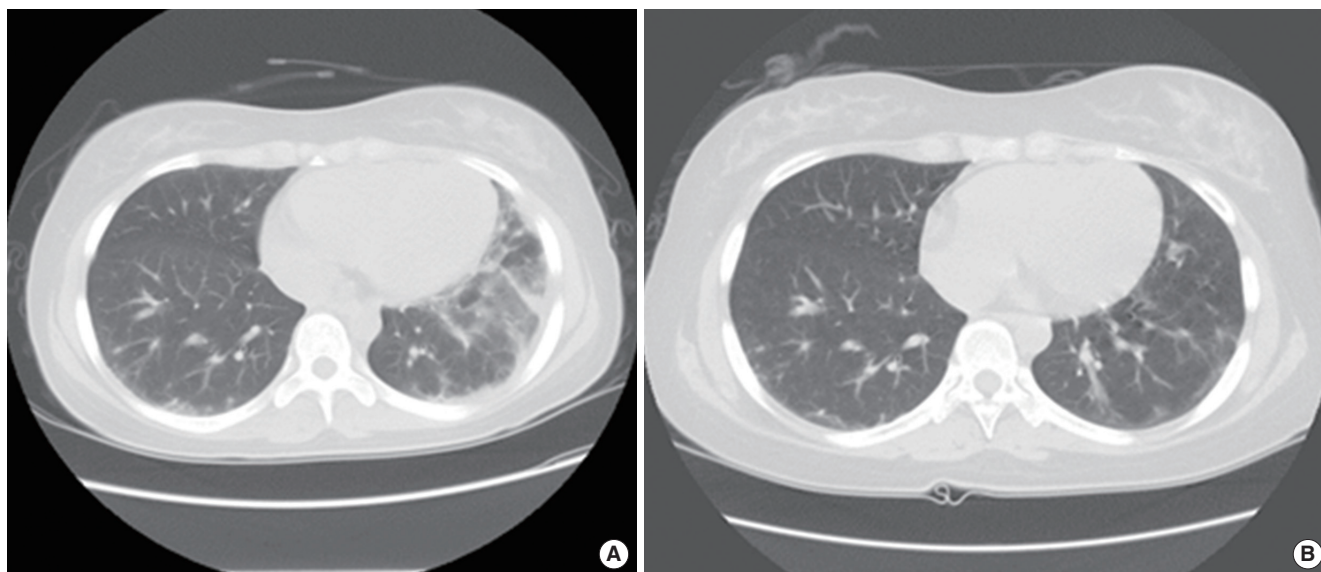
(A) Initial chest CT scan showed subpleural and peribronchovascular consolidation and ground-glass opacity in both lungs and (B) bilateral pleural effusions, which had improved on follow-up CT scan approximately 3 months later. CT, computed tomography.
